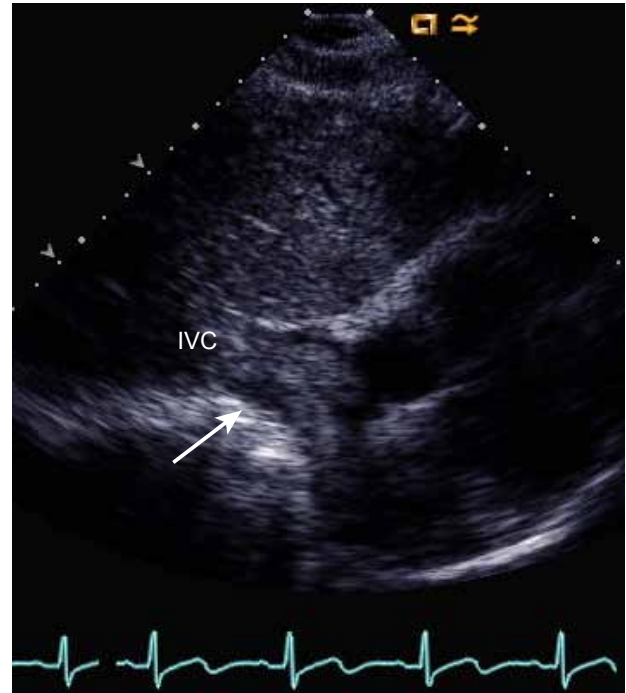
Transthoracic subcostal view demonstrating a mass invading the heart through the inferior vena cava (IVC).
